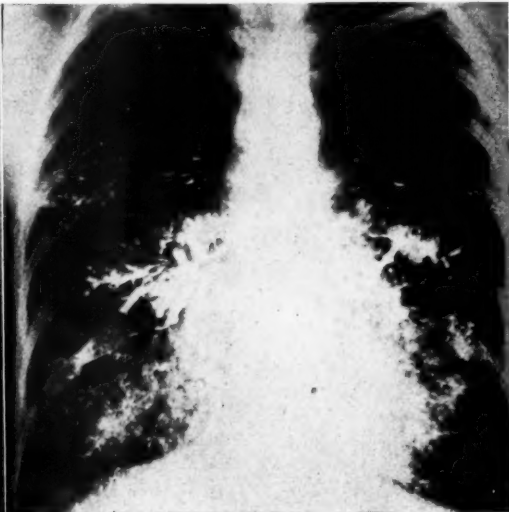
Roentgenogram of the chest of a woman of thirty-one years after lipiodol had been introduced into each bronchial tree. Case of bronchiectasis.
